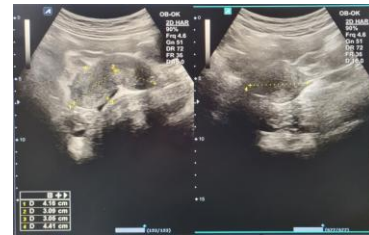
Ultrasound findings
